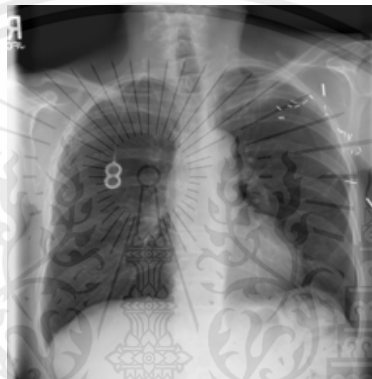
Example of Atelectasis chest X-Ray image (Wang, Yifan Peng, Le Lu, Zhiyong Lu, & Ronald M. Summers, 2018)
